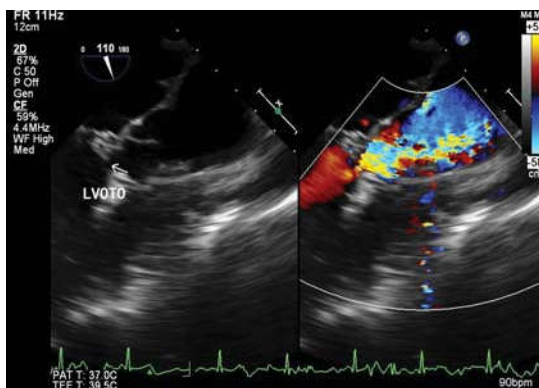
Transesophageal Echocardiographic midesophageal color compare aortic valve long axis view at 110° showing left ventricular outflow tract obstruction (LVOTO).
